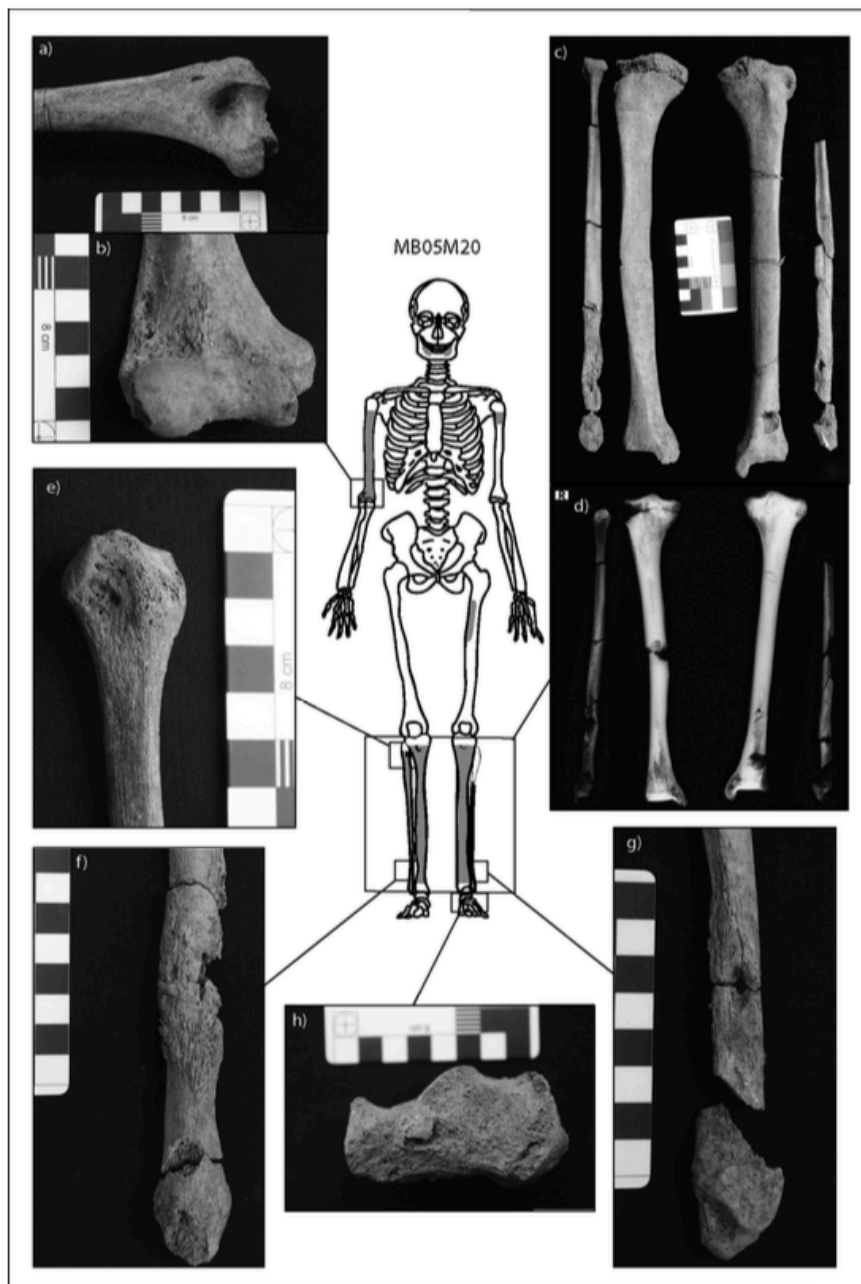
Expression of lesions related to infectious disease in M20. Preserved bones are outlined in black, with absent bones outlined in light gray. The skeletal extent of osteoblastic lesions is indicated by dark gray fill. (a) and (b) Superficial focal cavitations with smooth sclerotic margins not within distinct nodes of new bone on the anterior and posterior lateral epicondyle of the right humerus. (c) Remodeled cortical enlargements throughout the shafts of the tibiae with striated nodes of new bone on the distal fibulae. (d) Radiographs of the tibiae and fibulae: a distinct node of new bone with medullary intrusion is present on the medial middle shaft of the right tibia. The nodes of new bone of the distal fibulae are radiolucent due to the extent of pathological change to the internal cortex of the bone. (e) Superficial focal cavitation not within a distinct node of new bone on the proximal right fibula. (f) Two focal superficial cavitations on the lateral aspect of the right distal fibula within a distinct node of striated new bone. (g) Focal superficial cavitation on the medial aspect of the right distal fibula within a distinct node of striated new bone. (h) Focal superficial cavitation on the medial left calcaneal body, not within a distinct node of new bone. (Image: M. Vlok)
